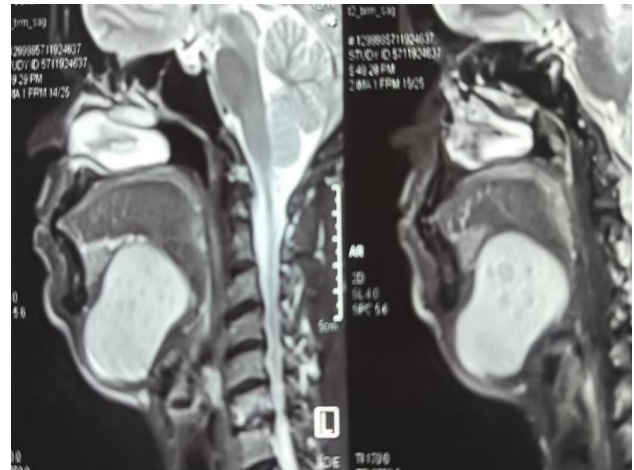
Sagittal MRI images showing a large, well-circumscribed cystic mass in the sublingual space with inferior extension into the submental region. The lesion appears hyperintense on T2-weighted sequences with internal heterogeneity, suggestive of a dermoid cyst.
